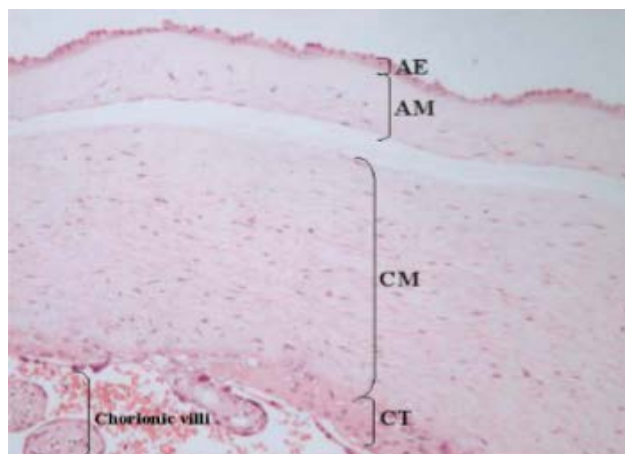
Corte transversal de membranas fetais humanas (âmnio e cório). O âmnio é composto por uma camada epitelial de células cubóides e colunares, as quais se encontram sobre uma camada mesodérmica, constituída por uma camada compacta acelular superior e uma camada mais profunda contendo fibroblastos dispersos. A membrana coriônica consiste de uma camada mesodermal e uma camada de células trofoblásticas extravilosas. Abreviaturas: AE; epitélio amniótico; AM, mesoderme amniótica; CM, mesoderme coriônica; CT, trofoblasto coriônico. Fonte: Parolini et al. (2008)
